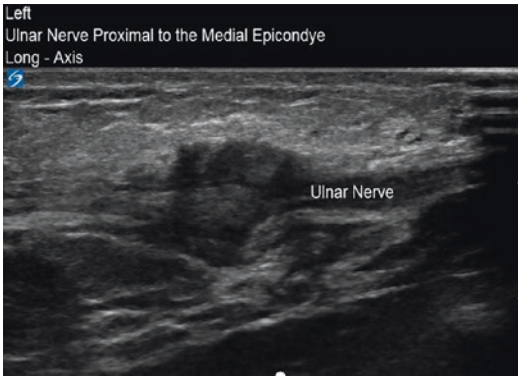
Ultrasound of a neuroma. An ulnar nerve neuroma is imaged just proximal to the medial epicondyle – note the large bulbous structure consistent with a neuroma continuous with the normal caliber of the ulnar nerve proximally
